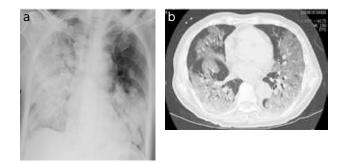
Chest radiography and computed tomography images at admission. The radiograph (a) and computed tomography
